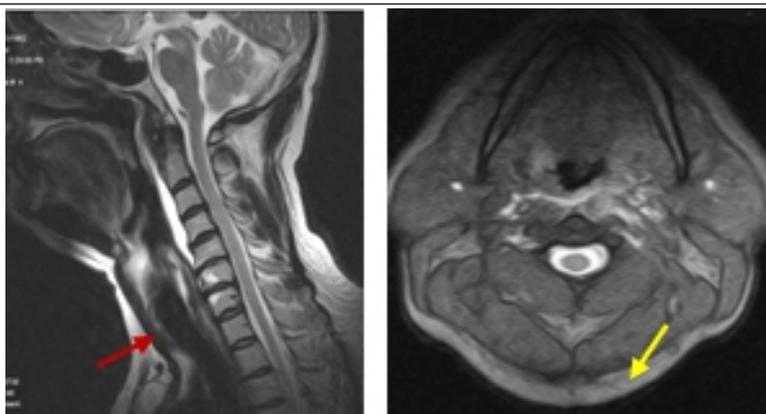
Magnetic resonance imaging images of case 2 showing (a) prevertebral fluid collection and (b) inflammatory edema in the left longus colli muscle T2 sagittal and axial T2 images.
